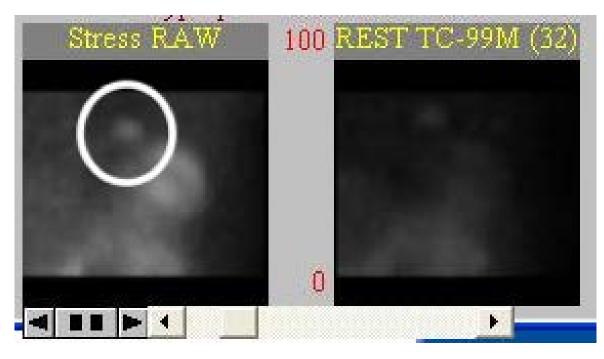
60 years old female with chest pain that led to the diagnosis of thymoma. Enlarged raw images (rotatogram) of the SPECT with extracardiac activity encircled.
